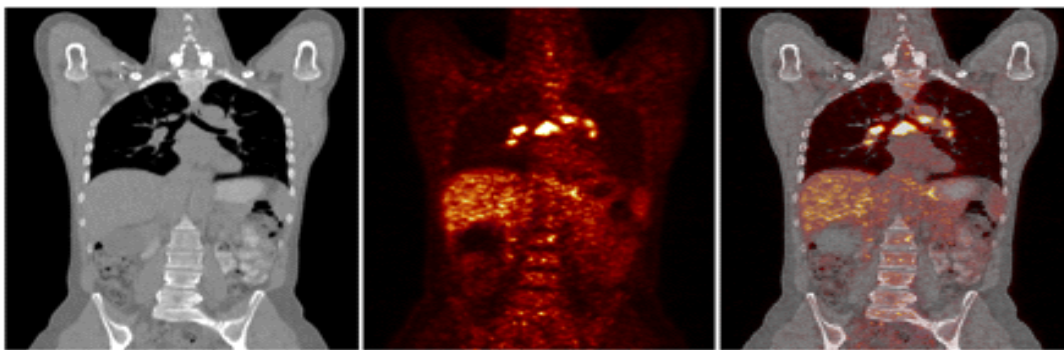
Attenuation map (left), PET images (middle), and fused PET/CT images (right) of patient with multiple [<sup>18</sup>F]FDG–avid mediastinal and bihilar lymph node metastases.[20]
